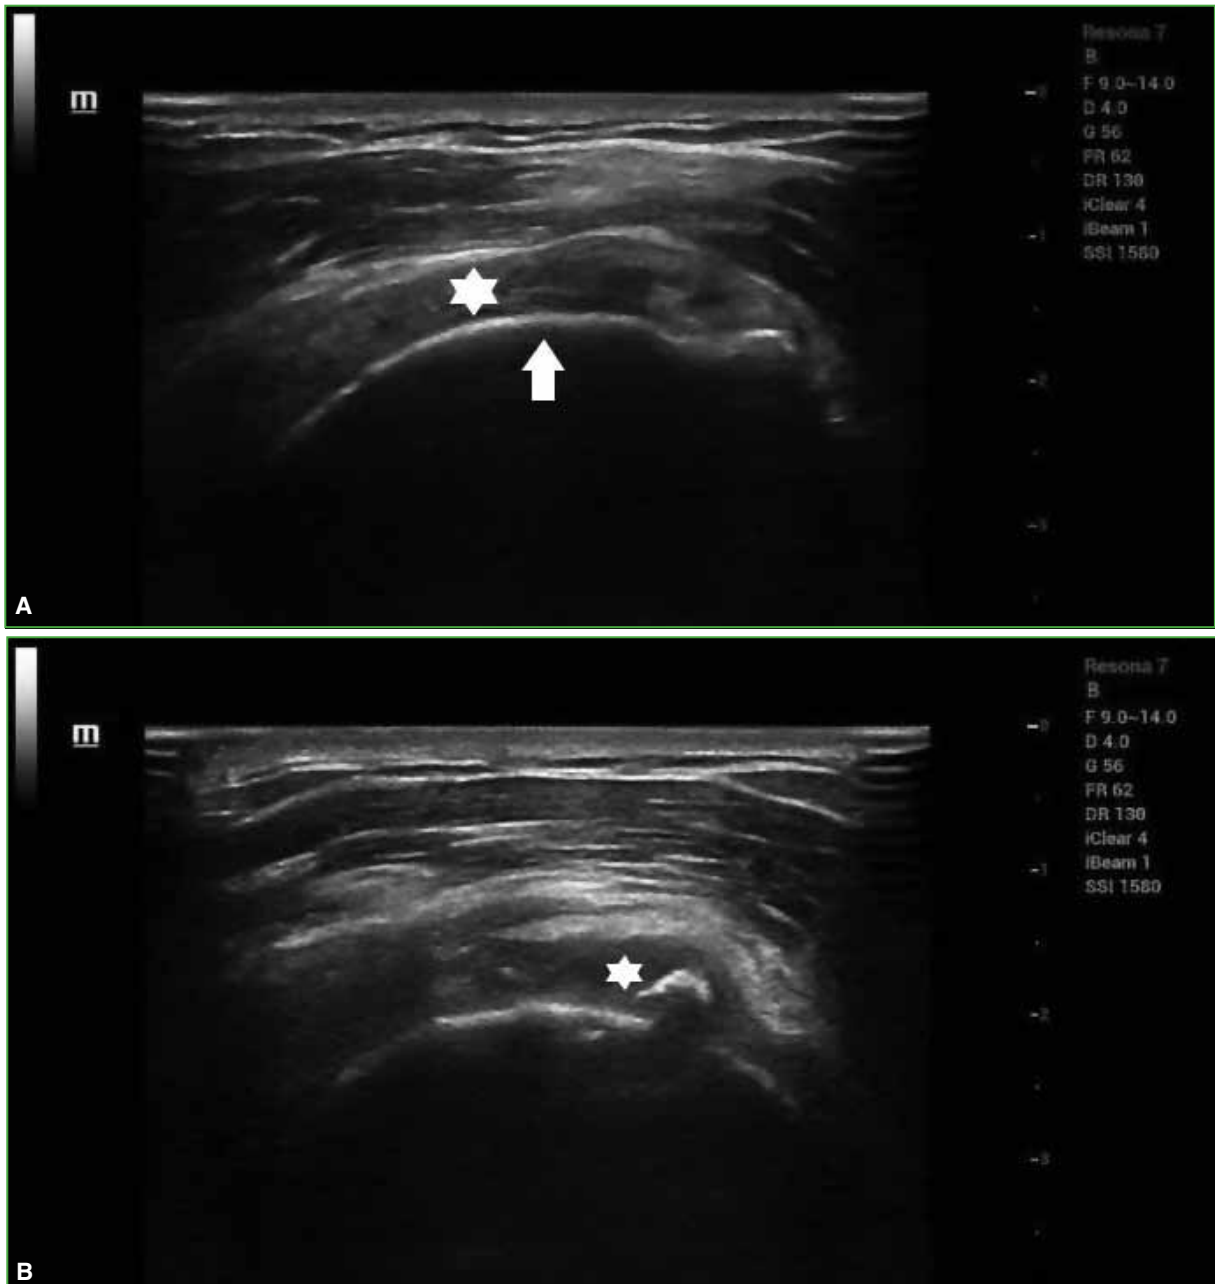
Left shoulder ultrasound. A. Complete tear of the supraspinatus (asterisk). The arrow marks the cortical bone of the humerus. B. Calcification in the topography of the infraspinatus (asterisk).
